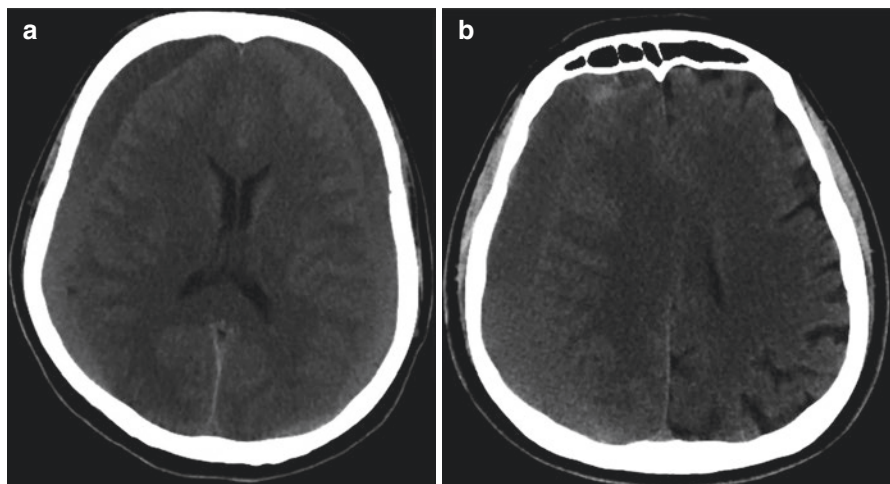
Axial CT image of two different patients. (a) In the patient with bilateral subdural hemorrhage, fluid-fluid layering is observed in the bilateral frontoparietal region, as a result of the collapse of the dense hemorrhagic contents. (b) The patient with chronic subdural hematoma in the right frontoparietal region has hyperdensity of acute hemorrhage in the frontal region and hematocrit effect secondary to this in the posterior location
